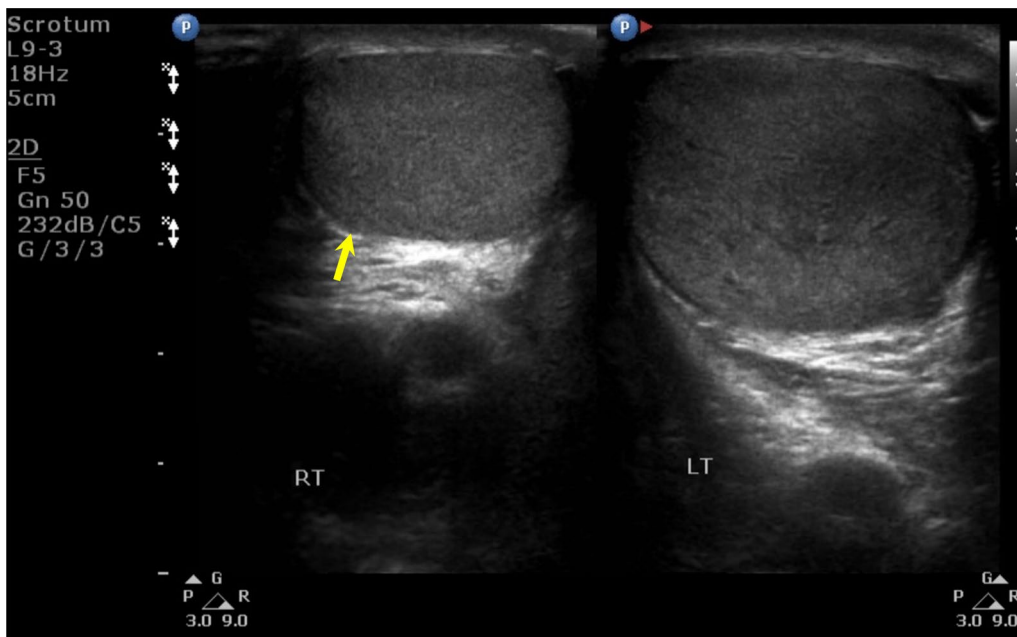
Ultrasound (transverse view) of the right testis shows that it is normal in size and homogenous in appearance
